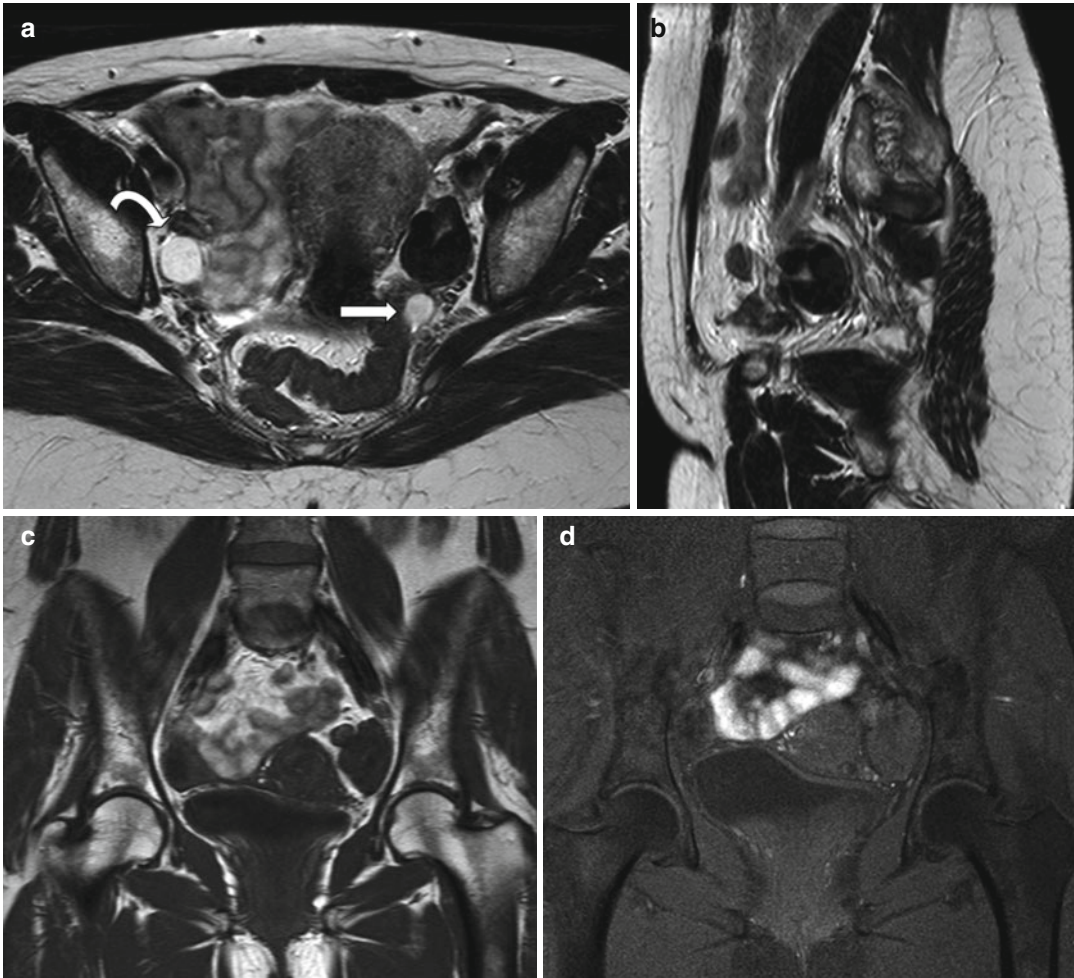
Ovarian fibroma. A 55-year-old lady with pain on the left pelvis. Left ovarian mass showing very low signal intensity on T2-weighted images (axial and sagittal T2-weighted images, TR:4361, TE:80; a, b) and low signal intensity on T1-weighted image (coronal
